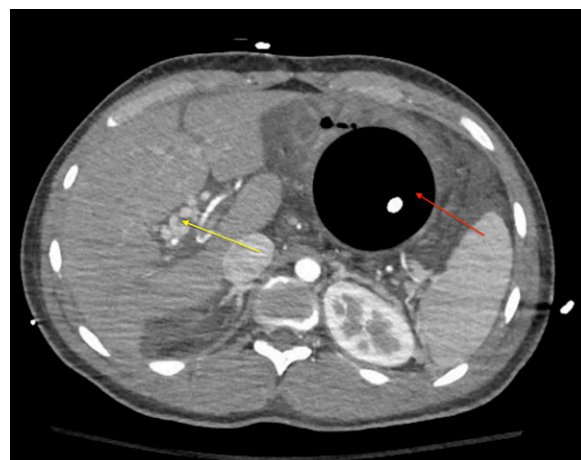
Computed tomographic scan of the abdomen demonstrating cavernous transformation of the portal vein with collateral formation (yellow arrow) and the presence of a Sengstaken-Blakemore tube (red arrow).
